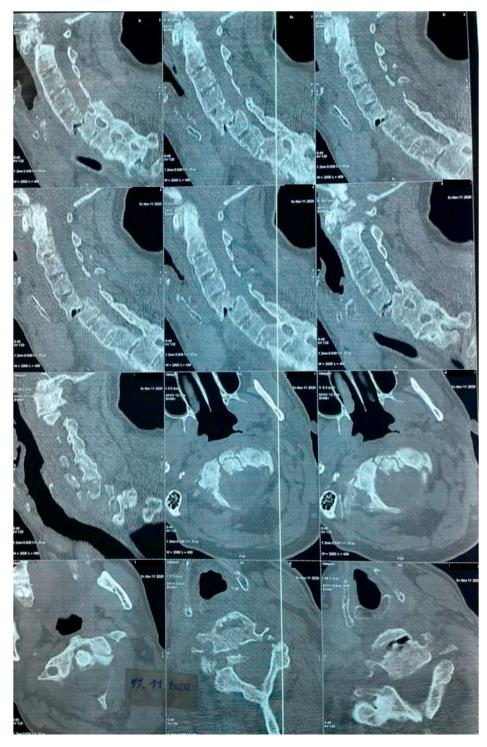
Cervical CT-SCAN shows a dislocation fracture of C5-C6.
